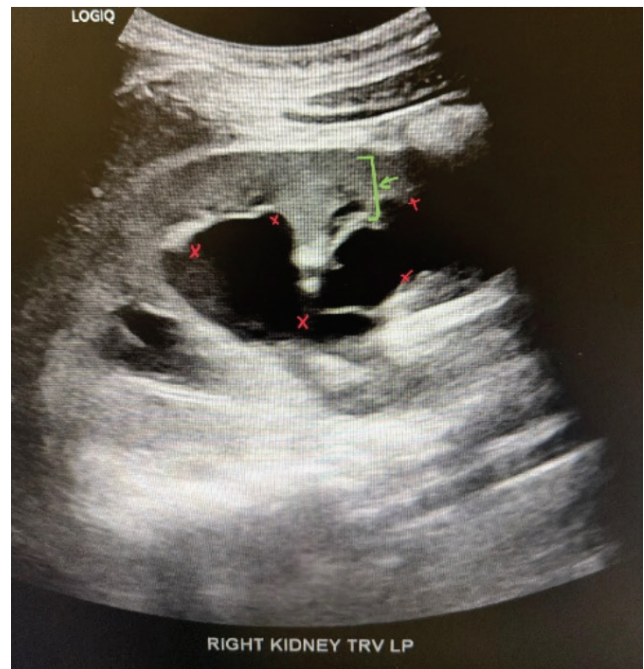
Retroperitoneal ultrasound demonstrating right-sided hydronephrosis. Retroperitoneal ultrasound showing severe right-sided hydronephrosis due to ureteropelvic junction obstruction, with marked dilatation of the renal pelvis and calyces (red x) and cortical thinning (green arrow)
